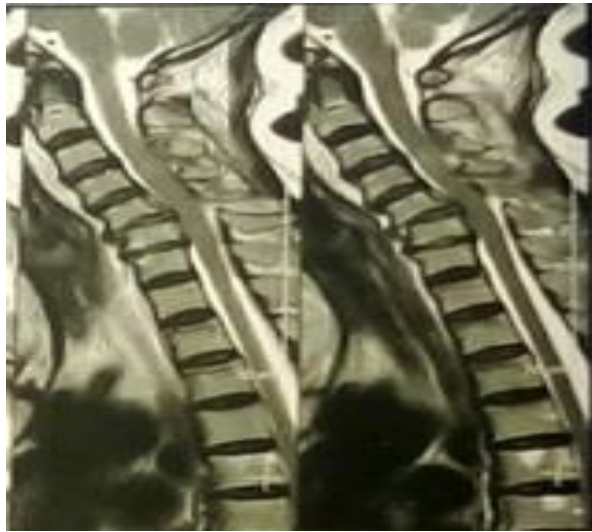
(A and B) MRI show displaced C4-5 with disrupted disc material, (C) Postoperative X rays show C4-5 fixation with peek cage and plate.
